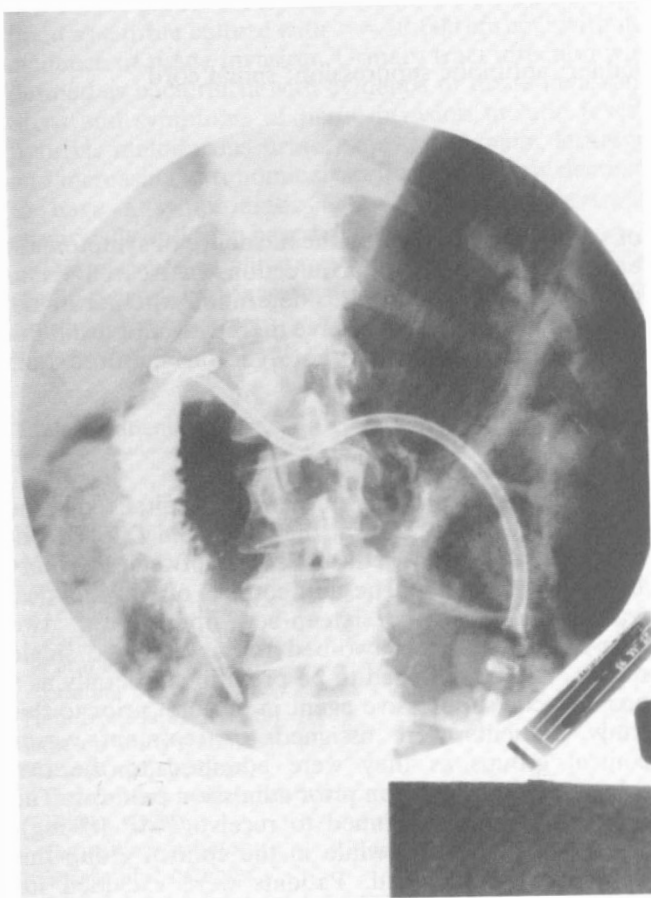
Radiograph of the short tube *in situ*. The loop will later move back to lie at the skin entry point so the tip may fall back into the stomach. A longer tube would be placed so that the tip lay in the distal duodenum
